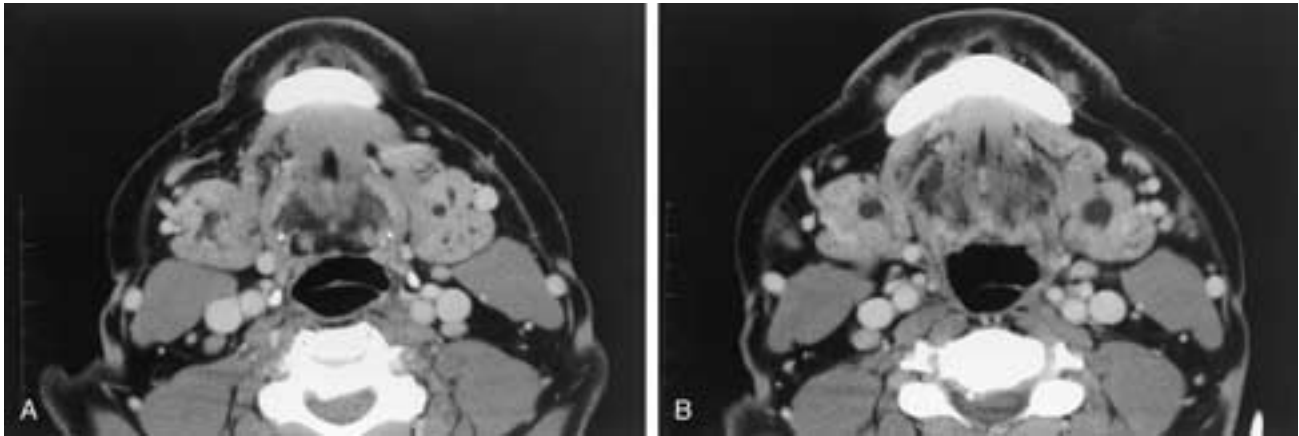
Bilateral intraglandular duct dilatation. A and B, Adjacent contrast-enhanced axial CT scans in a 33-year-old male with recurrent painful enlargement of both submandibular glands. Scans demonstrate marked enlargement of intraglandular ducts bilaterally, with no enlargement of the main duct and no calcified calculi identified.
